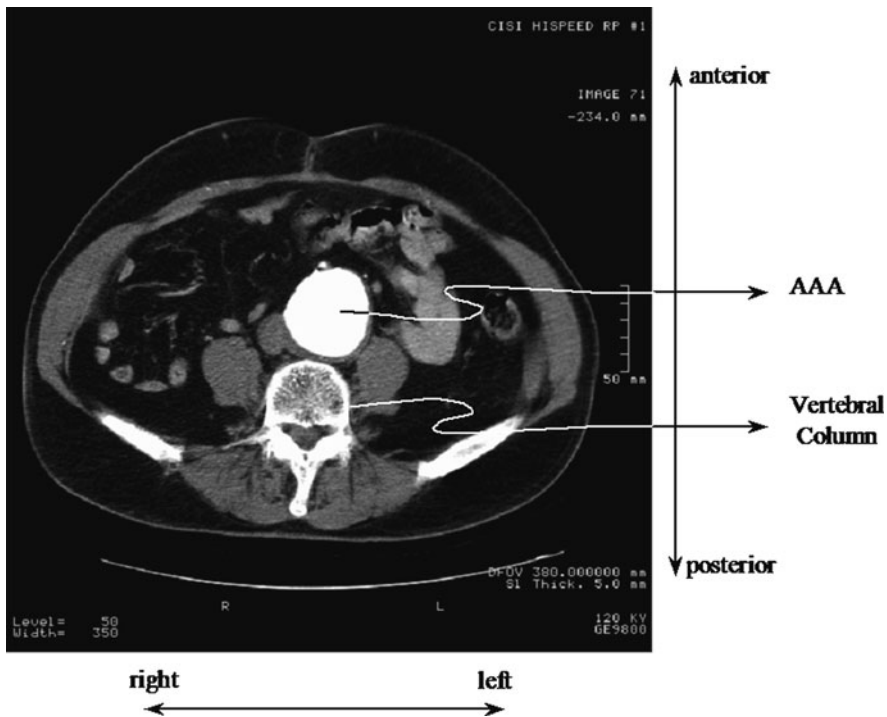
CTA of human AAA. The aneurysm is contrast enhanced in this scan
